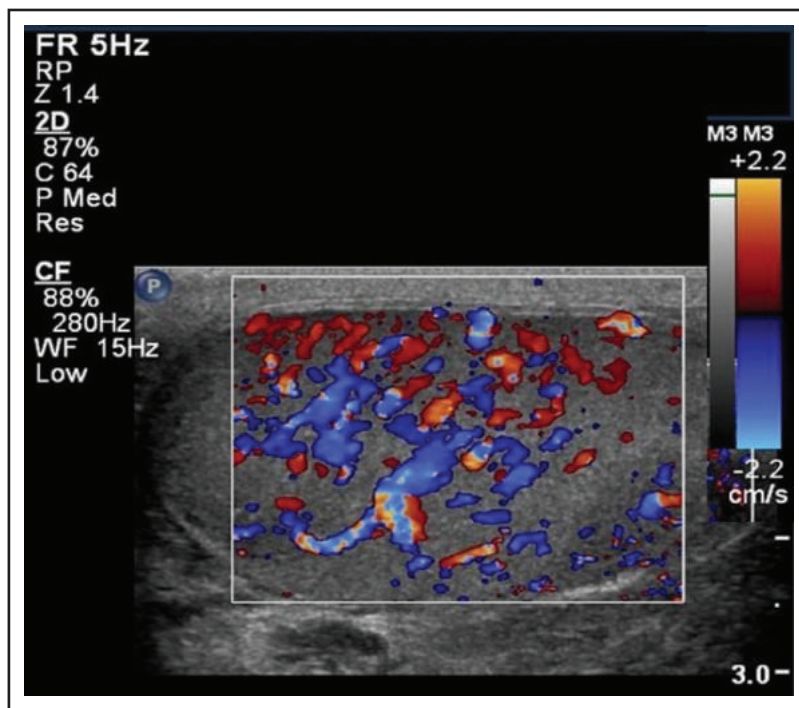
Colour Doppler. Sagittal colour Doppler image demonstrating testicular inferno.
